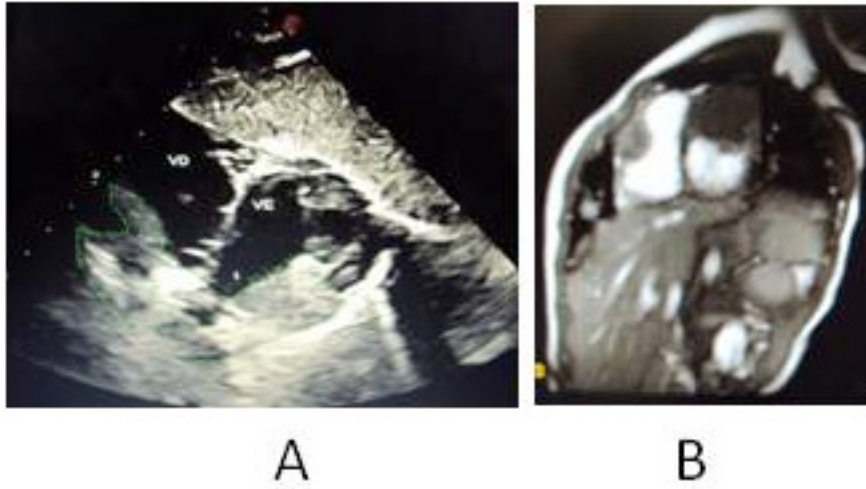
Echocardiogram, in cross-sectional view, showing the diagnostic elements of the biventricular intracavitary mass not causing obstruction to the flow (A). Tomography shows that the tumor on the left side fills the ventricular cavity more than does the tumor on the right side (B).
